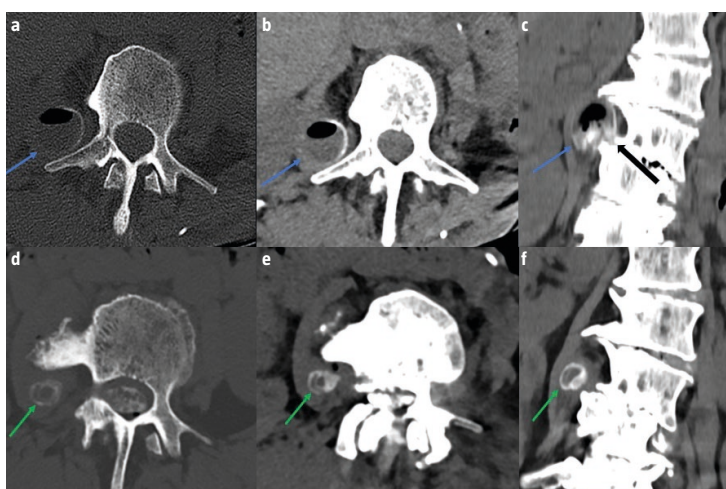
Lumbar spine computed tomography and computed tomography myelogram in the initial presentation (a-c) and after four months of follow-up treatment (d-f), respectively. Note is made for a lesion within the right psoas muscle at the level of L3 with peripheral calcifications and air-fluid level (blue arrows), with evolving decreased size and air-fluid level resolution (green arrows). The L3-L4 intervertebral disc communication is the clue for the correct diagnosis (black arrow).
